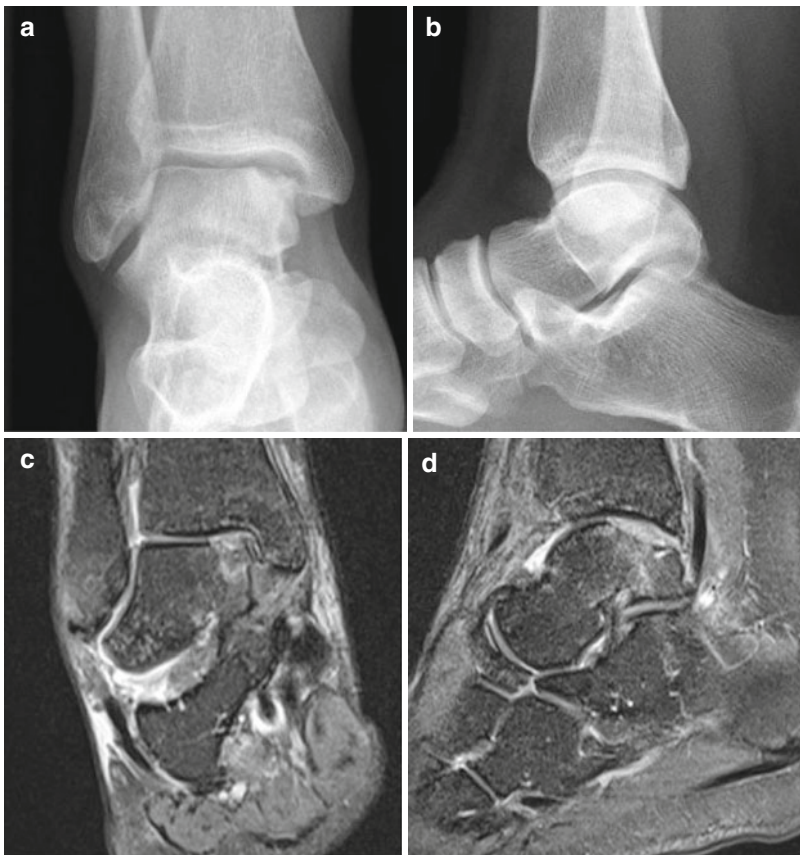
(a, b) Osteochondritis dissecans – diagnosis in X-ray. (c, d) Osteochondritis dissecans – diagnosis in MRI
